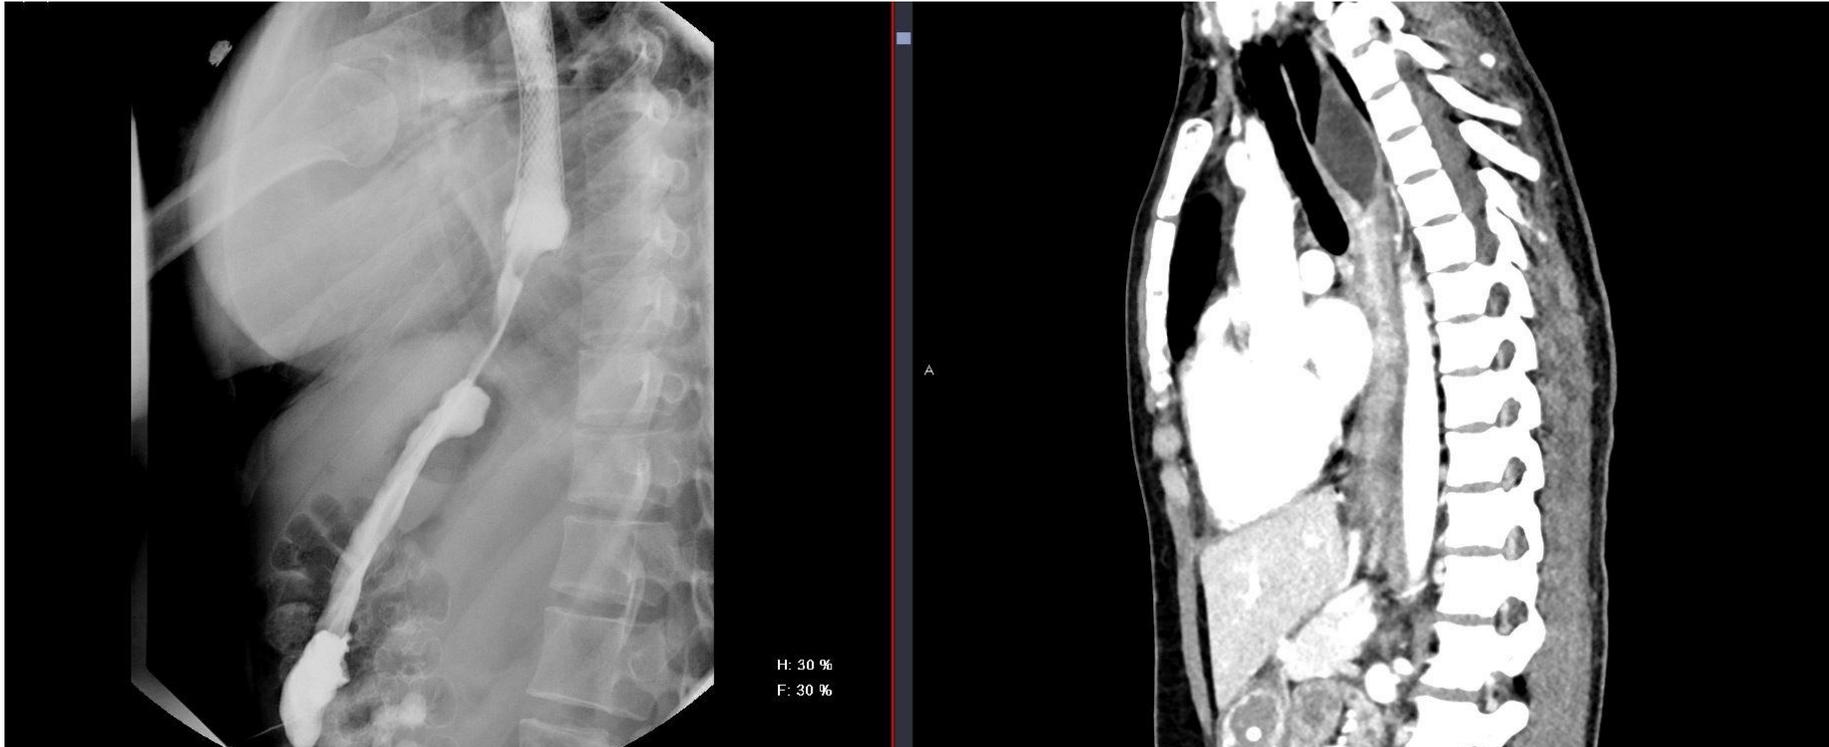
Subsequent fluoroscopic upper GI examination showing free contrast passage through the stented esophagus, with direct sagittal comparison to the initial CT in the sagittal plane
